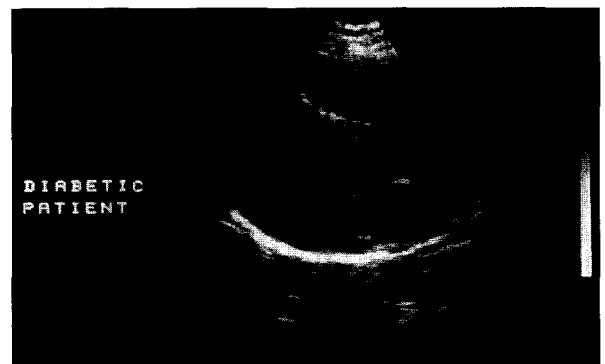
Top, Two-dimensional image showing left ventricular long-axis view, with the sample volume positioned on the septum strictly perpendicular to the ultrasound beam, in a diabetic patient. Bottom, Relative backscattered radiofrequency signal corresponding to the septal area.
